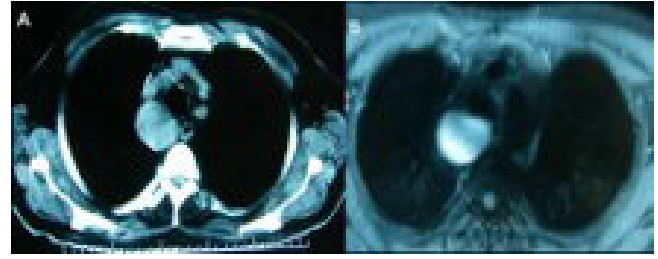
Enteric cyst is showed on computed thorax tomography (A), Enteric cyst is showed on magnetic resonance imaging (B).
